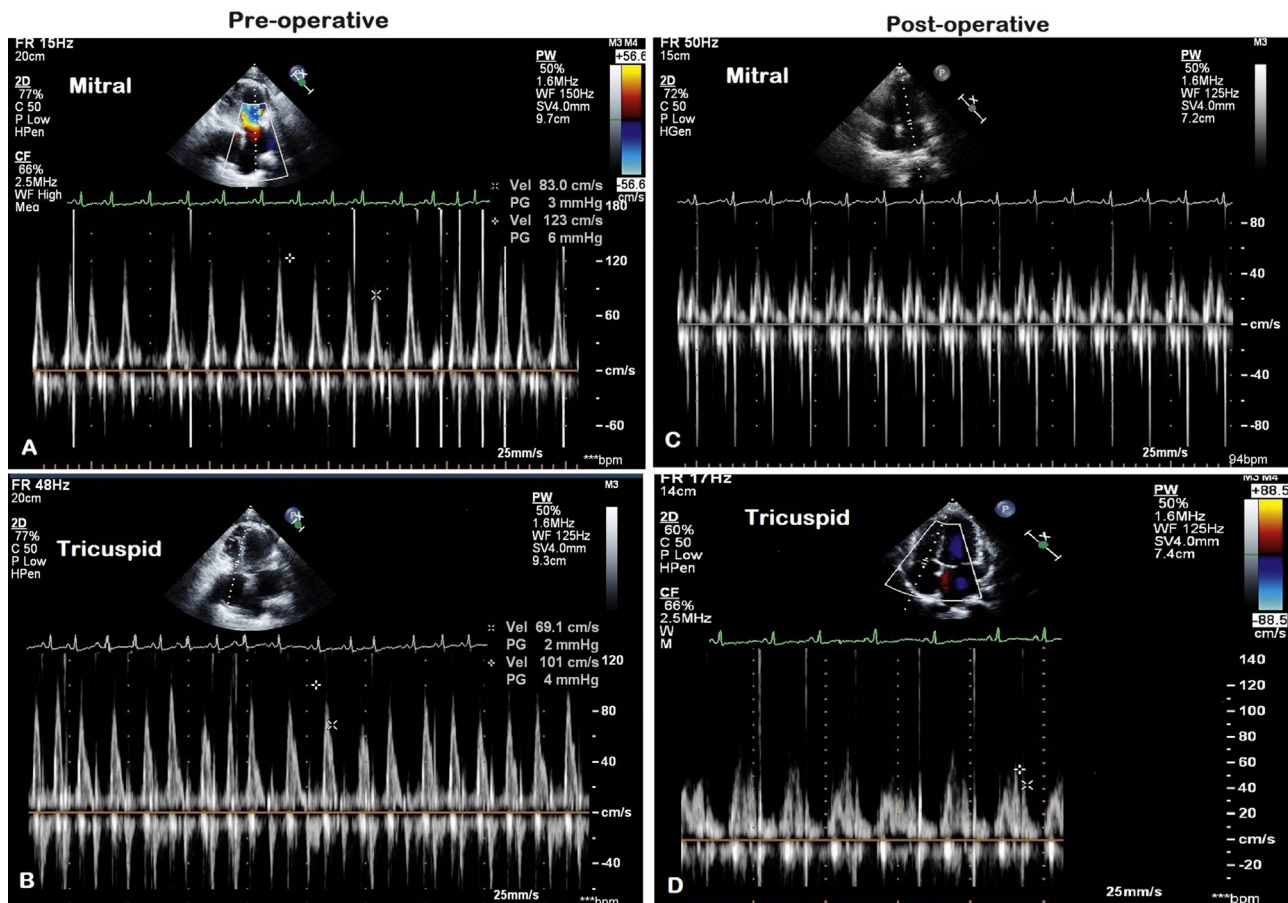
Image of the pulsed wave (PW) Doppler signals at the (A, C) mitral inflow and (B, D) tricuspid inflow region in a patient showing significant respiratory variation (A, B) pre-operatively as compared to the (C, D) post-operative PW Doppler signals.
